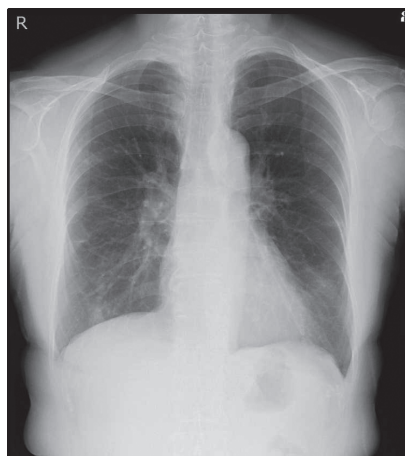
Chest radiography on first presentation to the hospital of the patient in Case 2
